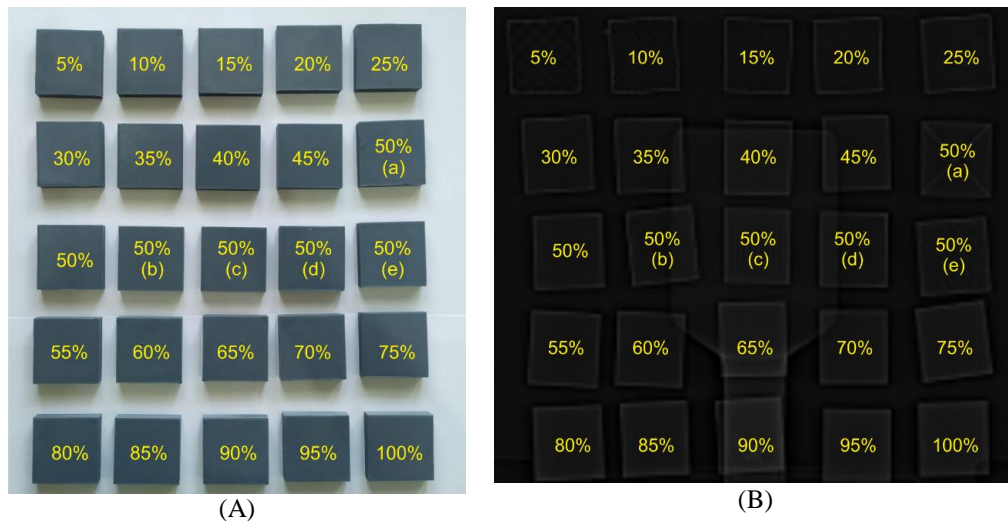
(A) Photographic image of samples from 5 – 100% infill, a) Concentric, b) Grid, c) Gyroid, d) Octet, e) Triangles. (B) Topogram image of the samples from 5 - 100% infill, ) Concentric, b) Grid, c) Gyroid, d) Octet, e) Triangles obtained from CT-Scan.
